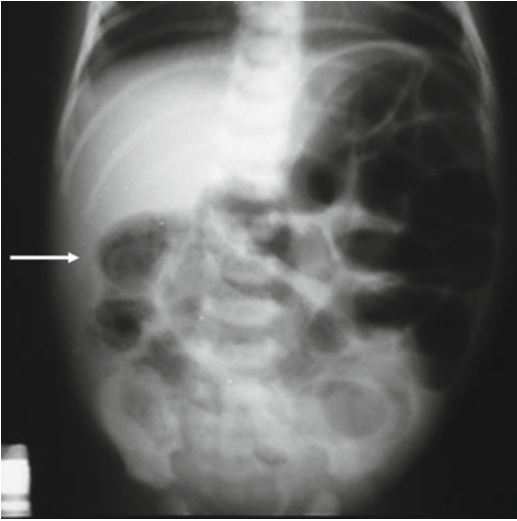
Plain film in newborn with meconium ileus. Note the abnormal distribution of the intraluminal air with proximal distended loops and the absence of gas in distal loops. There are no air-fluid levels. Note the “soap bubbles” and ground-glass aspects on the right flank
